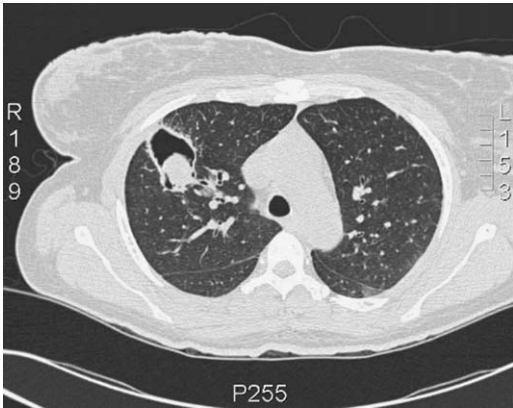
CT scan of an aspergilloma or fungus ball.
